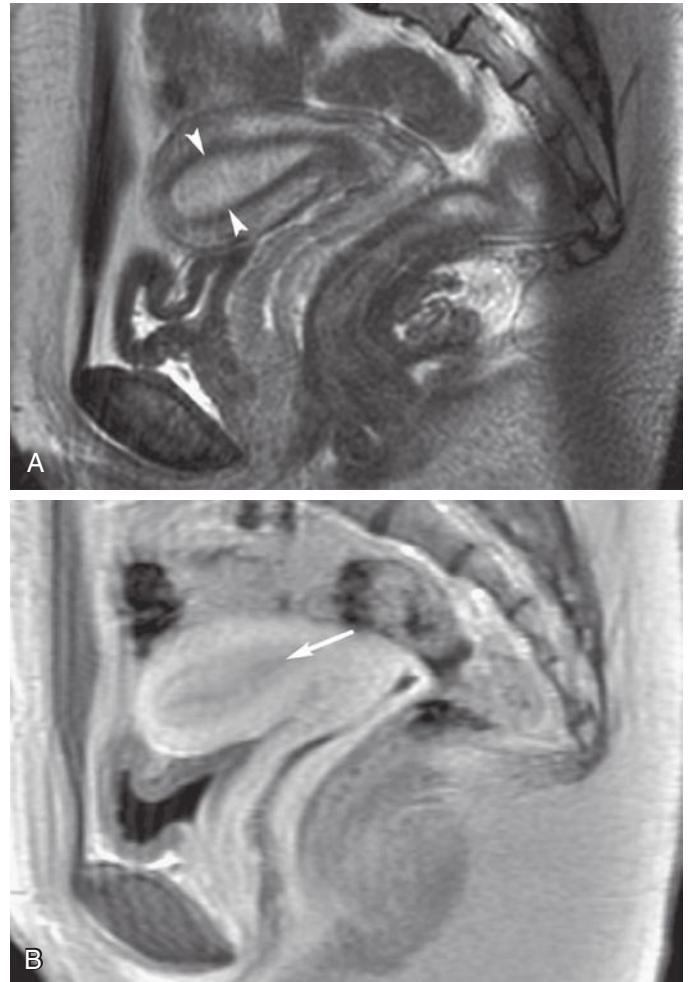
Apparent endometrial thickening. Sagittal T2-weighted (A) and postcontrast T1-weighted fat-suppressed (B) images. Apparent thickening of the endometrium is seen on the T2-weighted image (*arrowheads* in A); however, after administration of gadolinium, while the endometrium enhances, a dark central band of nonenhancing fluid within the cavity becomes evident (*arrow* in B).
